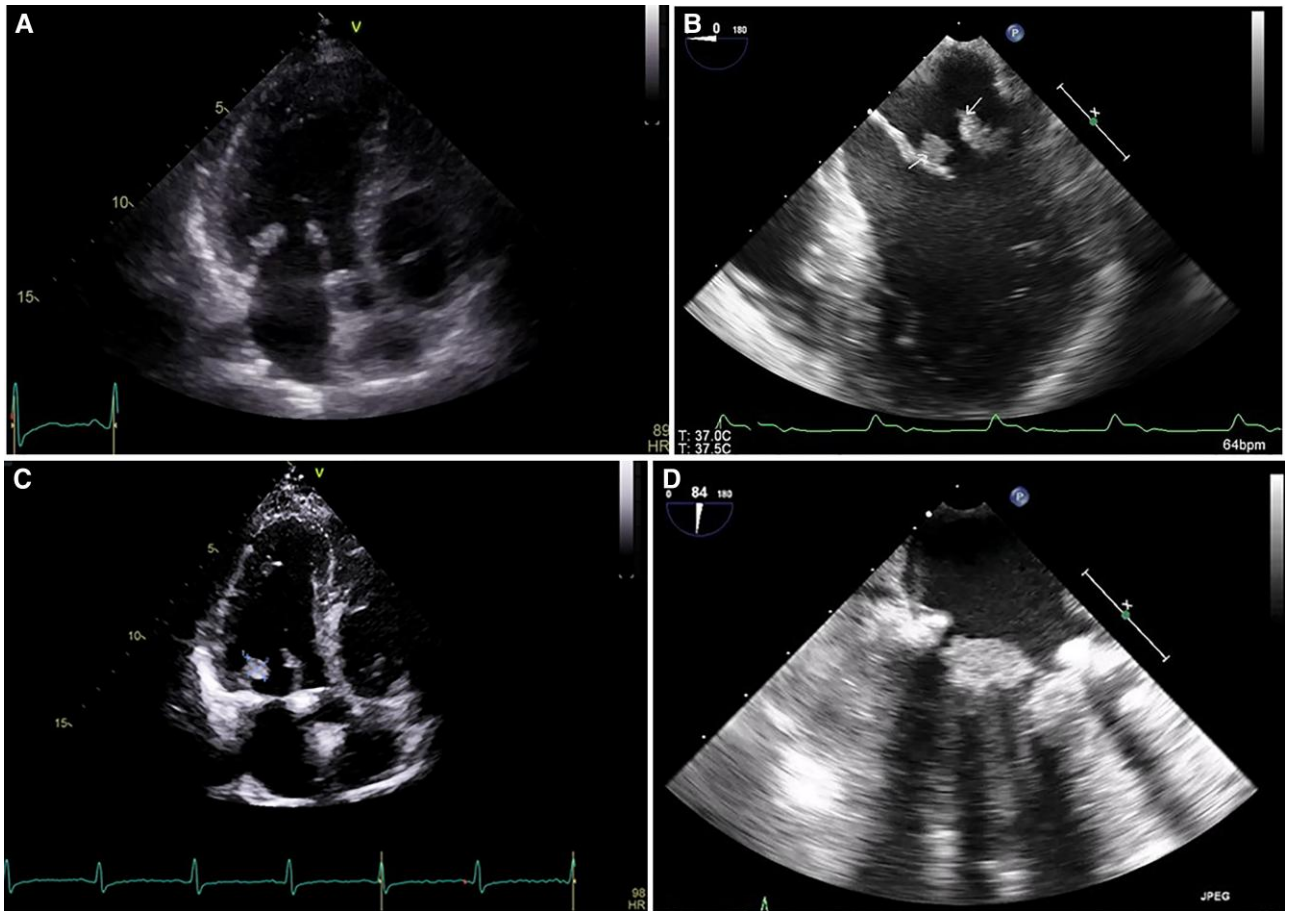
(A)TTE-apical four-chamber view showing masses attached to mitral leaflets. (B) TEE-midesophageal 2-chamber view showing masses on mitral leaflets. (C)TTE-apical four-chamber view showing recurrence of masses on mitral leaflets. (D) TEE-midesophageal two-chamber view showing recurrence of masses on mitral leaflets.
